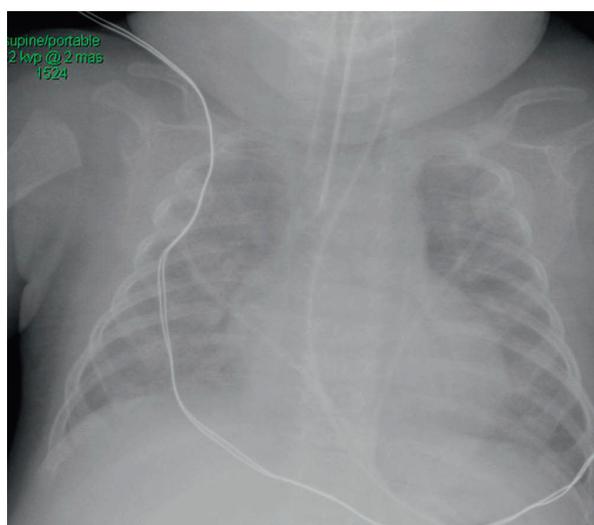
X-ray after intubation
